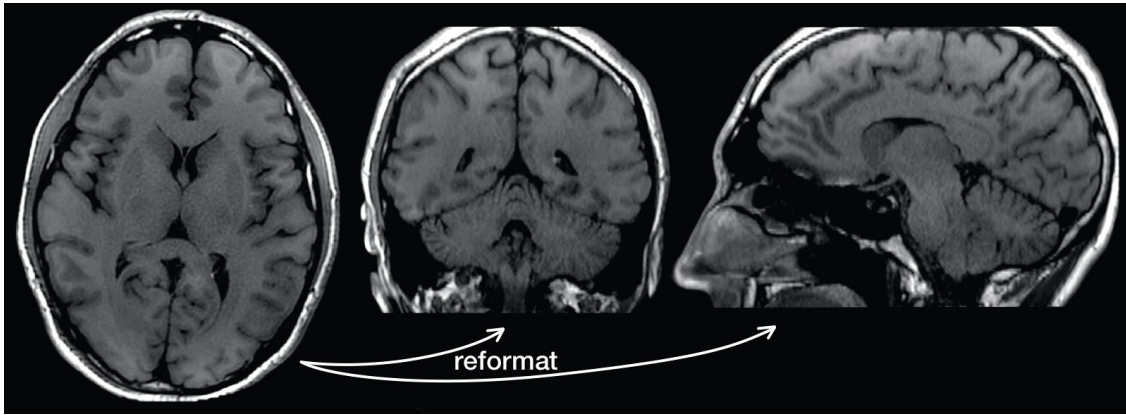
T1-FLAIR SMS accelerated PROPELLER. Axial slices and reformatted sagittal and coronal views. Scan parameters were as follows: $R = 2$, $SMS = 2$, $FOV = 240 \times 240 \text{ mm}^2$, $matrix = 240 \times 40$, $slice \text{ thickness} = 1.5 \text{ mm}$, $100 \text{ slices, exc./ref.}$ $FA = 90^\circ/111^\circ$, $RBW = \pm 50 \text{ kHz/FOV}$, $TE/TR = 13/1993 \text{ ms}$, $ETL = 10$, two acquisitions and a scan time of 3 min.*
